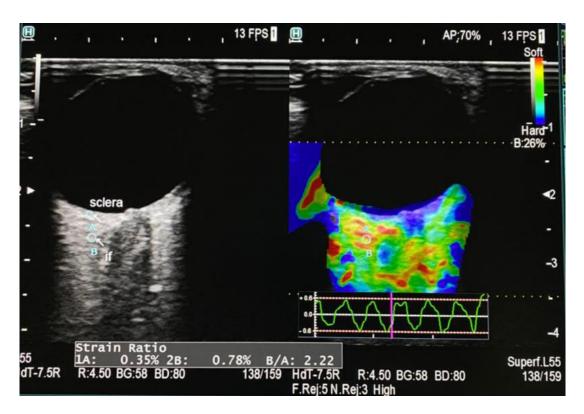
B-mode ultrasonography image (1) and the related elastography image (2) of scleral tissue (A) versus intraconal fat (B). The circles (A and B) indicate where the elastographic measurements were taken. B intraconal fat, A sclera tissue.
